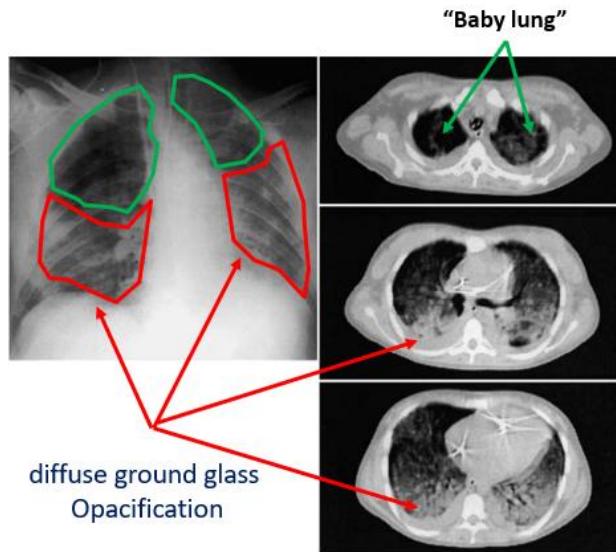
Chest X-Ray image and CT scans of ARDS lungs. The dark areas are aerated parts of the lung. The white diffuse ground glass area of the lung are collapsed fluid filled parts of the lung. (From Gattitoni, Presento , Applied Physiology in Intensive Care Medicine, 2009)
